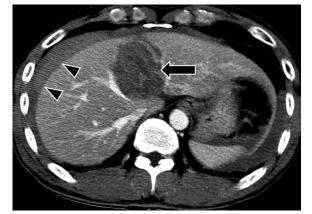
Intraparenchymal hematoma. Contrastenhanced CT scan shows a 5-cm intraparenchymal hematoma in the medial segment of the left hepatic lobe (arrow). Arrowheads indicate associated hemoperitoneum in the right subphrenic space.
